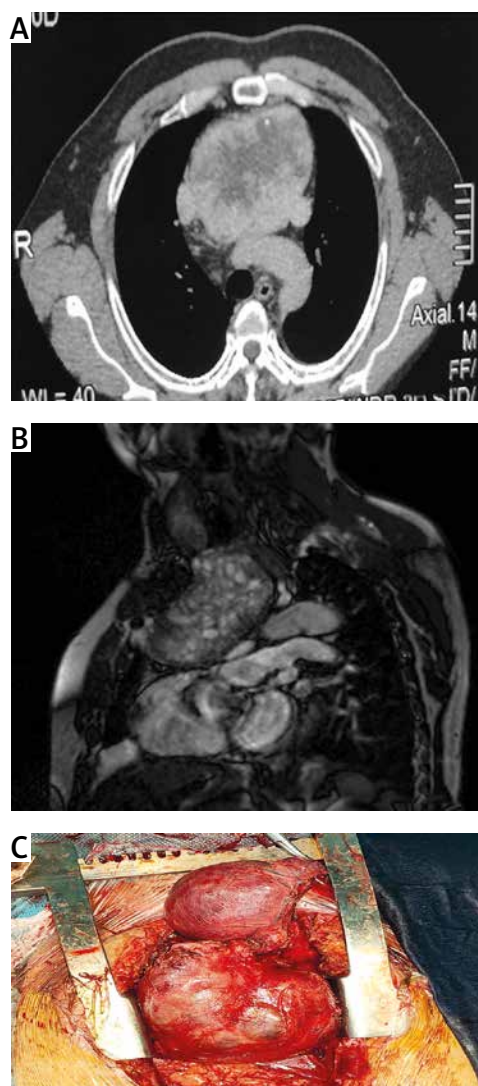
A – Transversal view of a CT scan showing the huge plunging goiter. B – Sagittal view of a CT scan showing the huge retrosternal goiter. C – Perioperative view of the cervical and thoracic part of the goiter extirpated via a cervico-sternotomy
